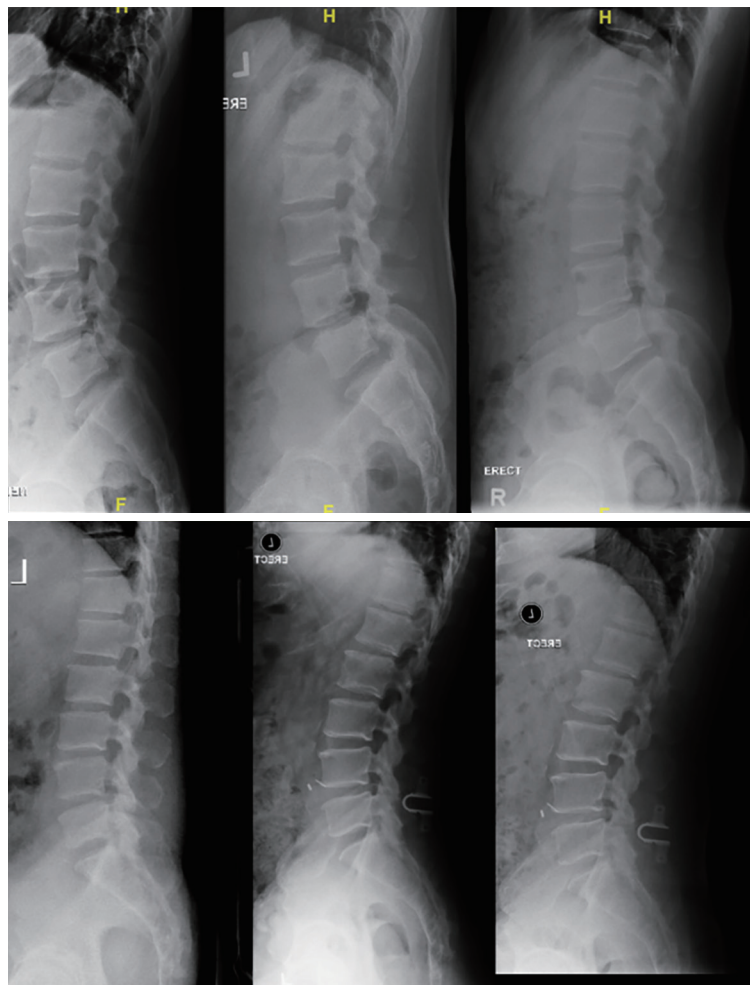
Lumbar spine lateral radiographs of a patient who underwent decompression surgery alone at preoperative, immediate postoperative and at 5 years (top left, top middle and top right). Lumbar spine lateral radiographs, taken while standing erect, of a patient who underwent decompression surgery with insertion of ILD at preoperative, immediate postoperative and at 5 years (bottom left, bottom middle and bottom right). ILD, interlaminar device.
